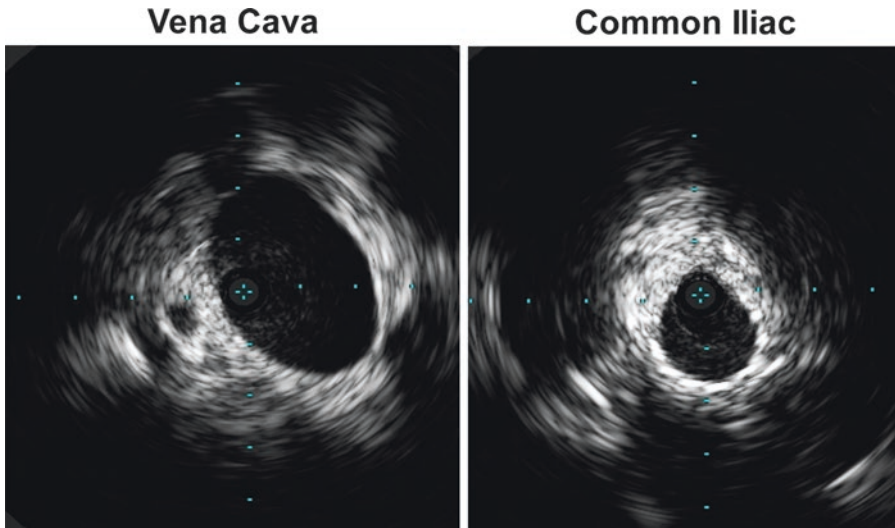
Completion intravascular ultrasound (IVUS) showing normal vena cava and normal common iliac vein
